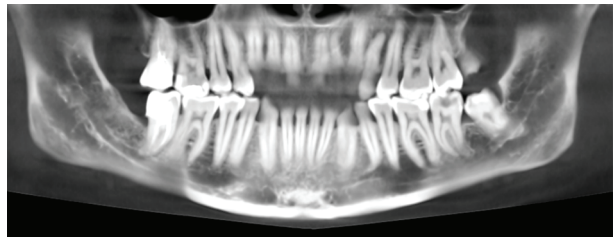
Coronal view of the preoperative CBCT.
